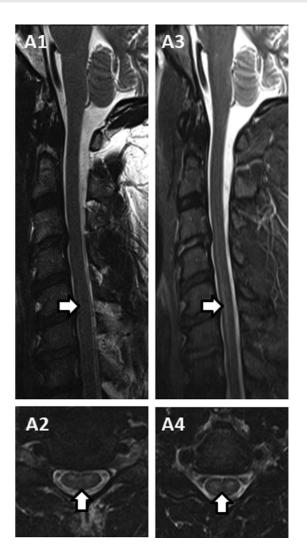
MRI features of spinal cord infarction. Sagittal T2-weighted imaging of cervical spinal cord appeared essentially normal other than perhaps very faint possible signal around C4–C6 region (A1, arrow). STIR imaging sequences revealed bright focal signal in this region, which has a long anterior signal consistent with pencil-like T2-hyperintensity (A3, arrow). This was corroborated on axial T2-weighted imaging showing ventral horn patchy T2-hyperintensity at multiple levels (A2, A4: arrows).
